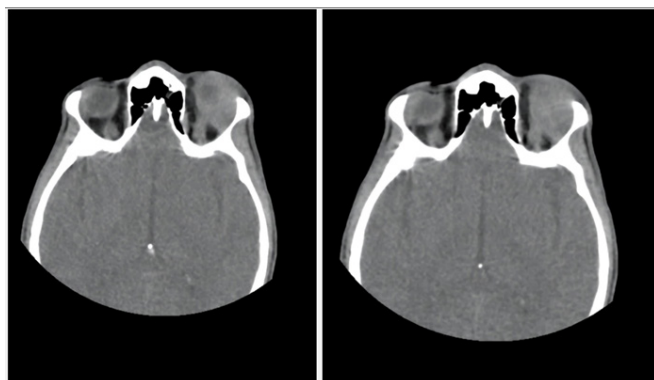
Contrast-enhanced computed tomography demonstrating a 34×23 mm superolateral left intraorbital lesion extending over 25 mm, involving the intraconal and extraconal compartments and producing grade I proptosis.
